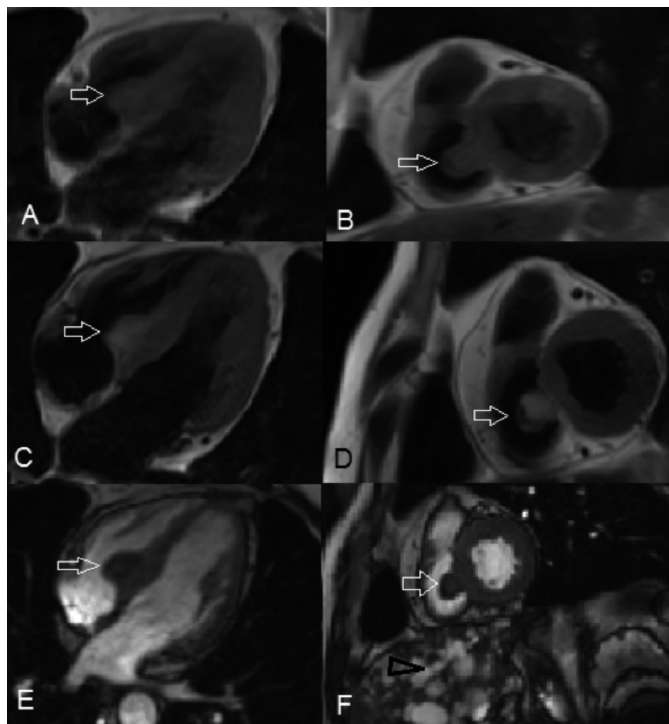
Cardiac magnetic resonance showing a fixed-cystic mass (arrows) with thick walls and attached to the interventricular septum without evidence of tricuspid valve dysfunction. A-B: T1-weighted image in four-chamber and short-axis views, C-D: T2-weighted image in four-chamber and short-axis views, E-F: Cine image in four-chamber and short-axis views (arrowhead; multiple hepatic cysts).
